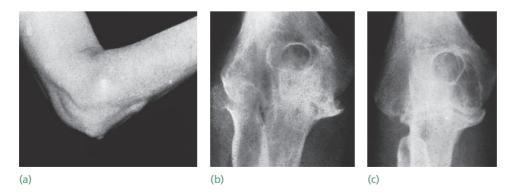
Rheumatoid arthritis (a) This rheumatoid patient has nodules over the olecranon and a bulge over the radiohumeral joint; (b) his X-rays show deformity of the radial head and marked erosion of the rest of the elbow. (c) Excision of the radial head combined with synovectomy relieved the pain and improved elbow movement.
